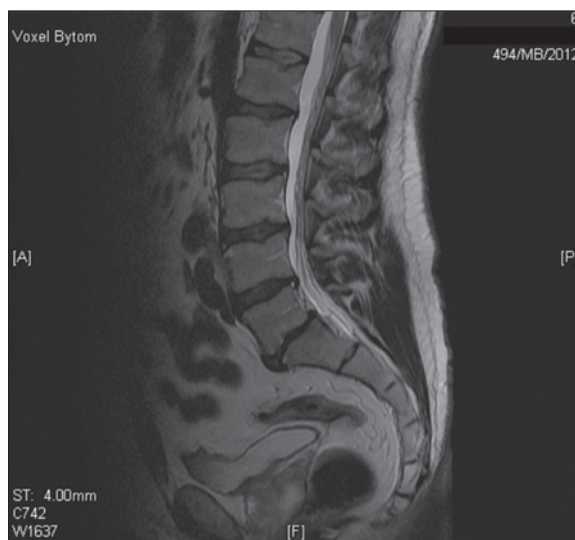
T2-weighted magnetic resonance scan obtained in a patient not diagnosed with myelodysplastic syndrome.
